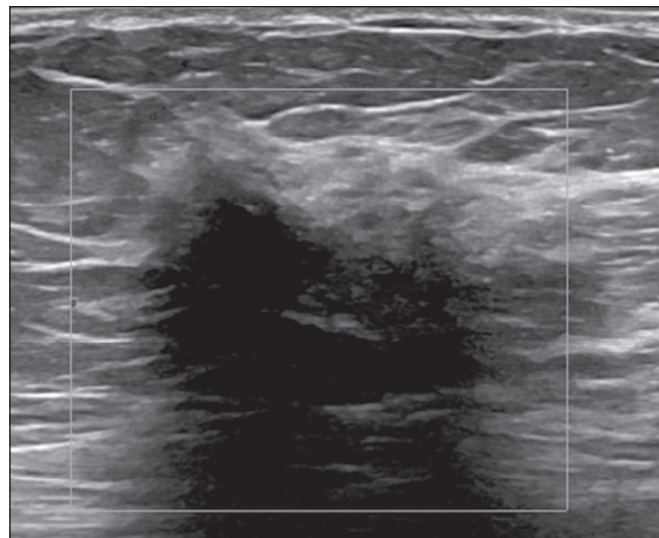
Ultrasound showing an irregular, spiculated, hypoechoic mass, with posterior acoustic shadowing, with no flow on Doppler evaluation. Percutaneous biopsy of the mass resulted in a diagnosis of peribulbar lymphocytic infiltrate, consistent with diabetic mastopathy.
